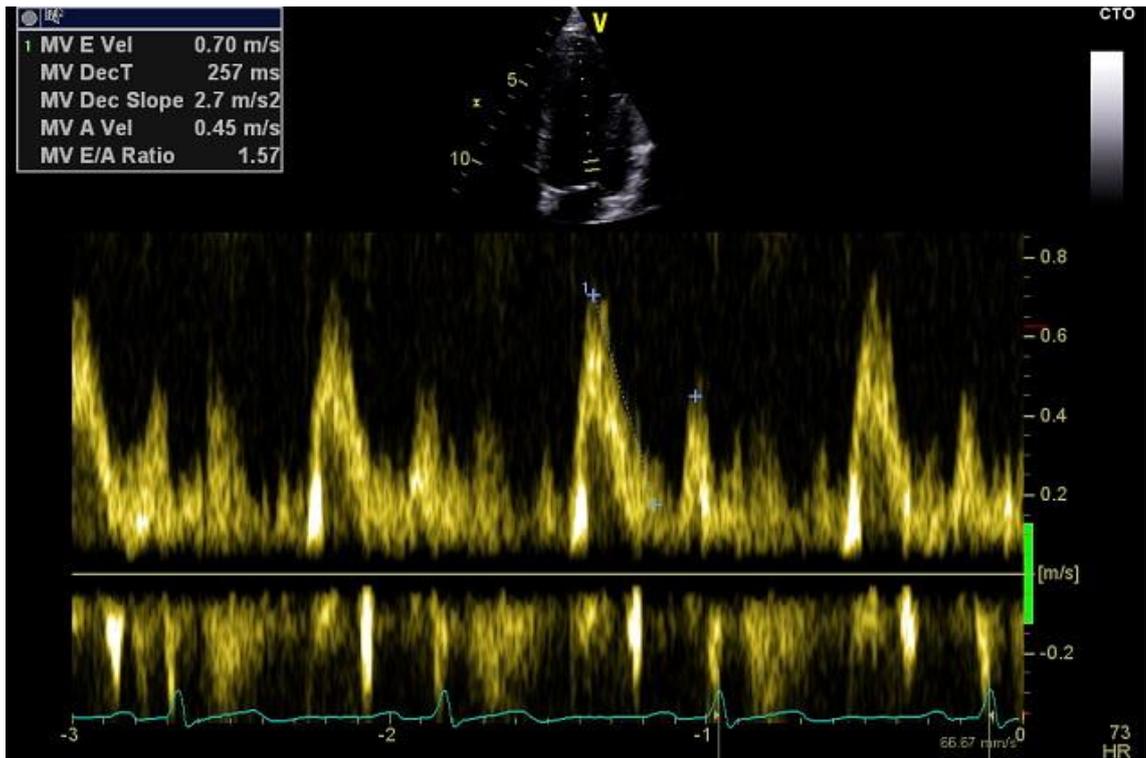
Transmitral Doppler mitral inflow demonstrating a normal mitral flow pattern
